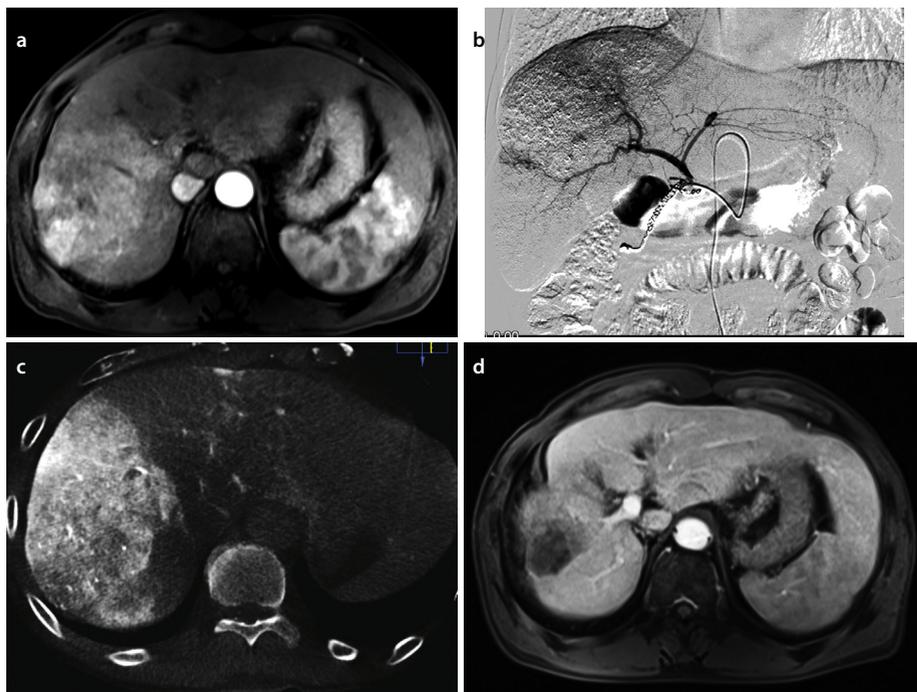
A 55-year-old male with hepatitis B virus, a Child–Pugh score of 5A, and refractory TACE. (a) An infiltrative right hepatic tumor with right portal vein tumor thrombosis. (b) Hepatic angiography via port when treated with hepatic arterial infusion chemotherapy (HAIC). (c) Contrast-enhanced cone-beam computed tomography (CT) on the day after port implantation: a right hyperperfusion tumor. (d) Follow-up contrast CT after five cycles of HAIC showing a complete response. TACE, transarterial chemoembolization.
